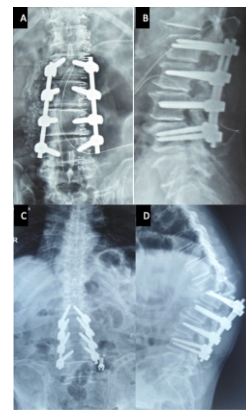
(A, B) 1st post-operative radiograph showing reasonable lordosis achieved with stabilization from L1 to L5 with postero-lateral bone grafting. (C, D) 5 months follow up with adjacent segment disease with proximal junctional kyphosis and toppling.
